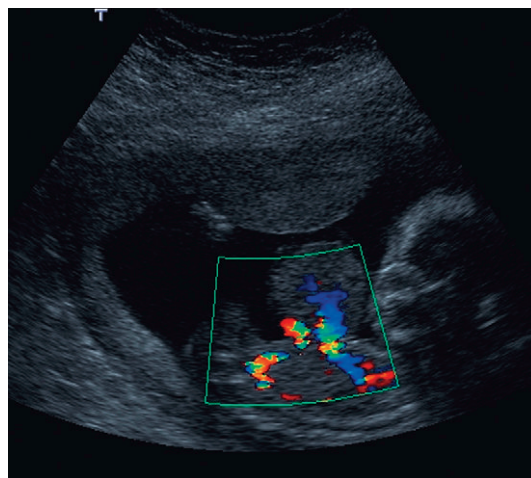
Omphalocele colour flow Doppler demonstrates abnormal vessels within the anterior abdominal wall defect.
